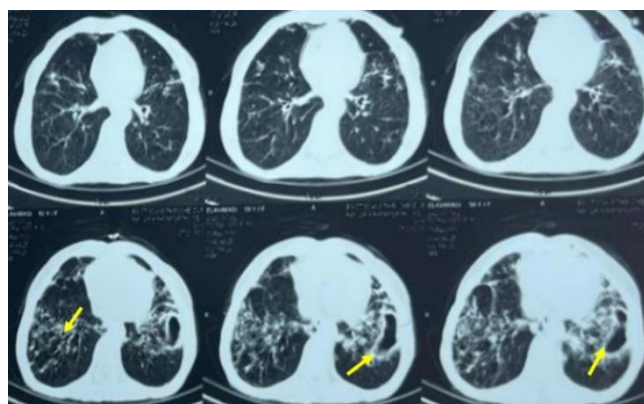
HRCT thorax showing left lower lobe cavity and tree in bud opacities in both lower lobes
